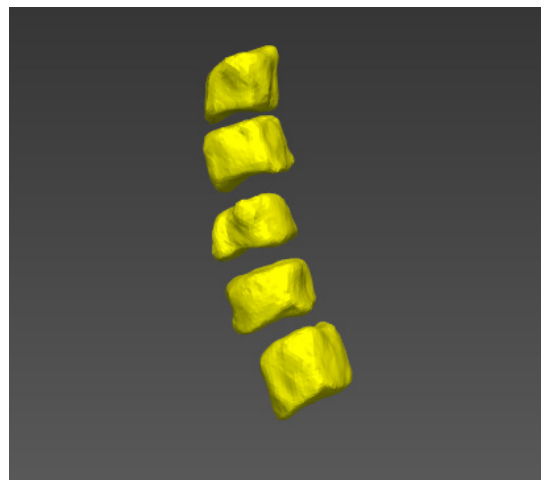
Segmentation of cervical vertebrae C3–C7 in MRI images based on Statistical Shape Models (SSM)
